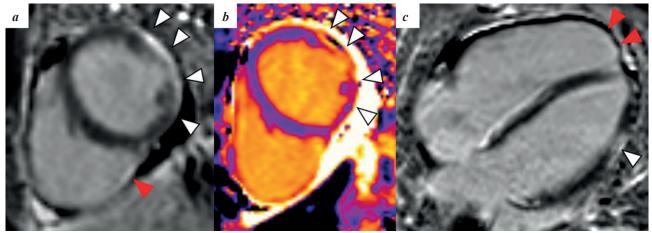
Magnetic resonance imaging of the heart of a 793c patient. with images of the heart in the delayed contrast enhancement sequence: end-diastolic phase, in short-axis projection (a), native T1-mapping (b), and four-chamber projection (c); areas of subepicardial and transmural fibrofatty replacement of the myocardium of the lateral wall of the left ventricle (white arrow heads), areas of fibrosis of the myocardium of the inferior wall and apex of the right ventricle (red arrow heads).
